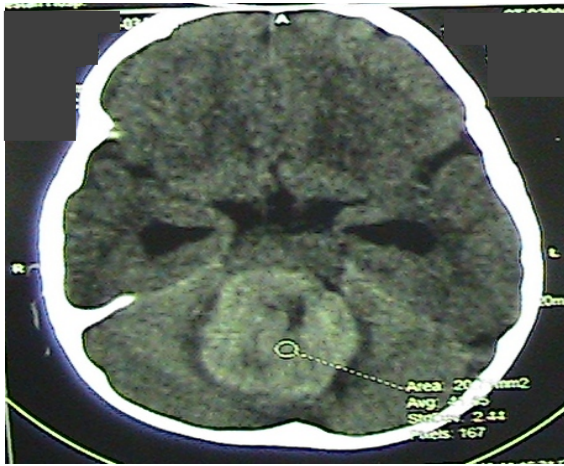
This figure shows brain CT scan at the time of diagnosis.
